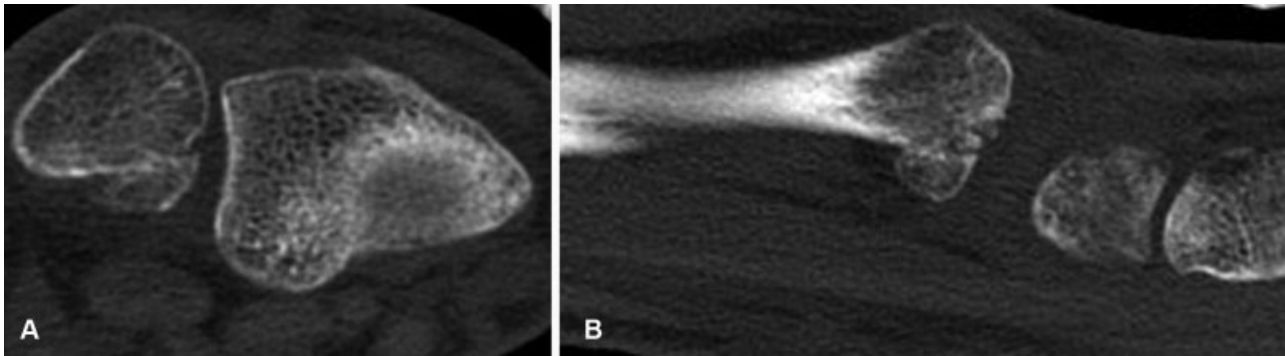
Preoperative computed tomography scan shows the partially consolidated fragment in a frontal view (A) and sagittal view (B).
